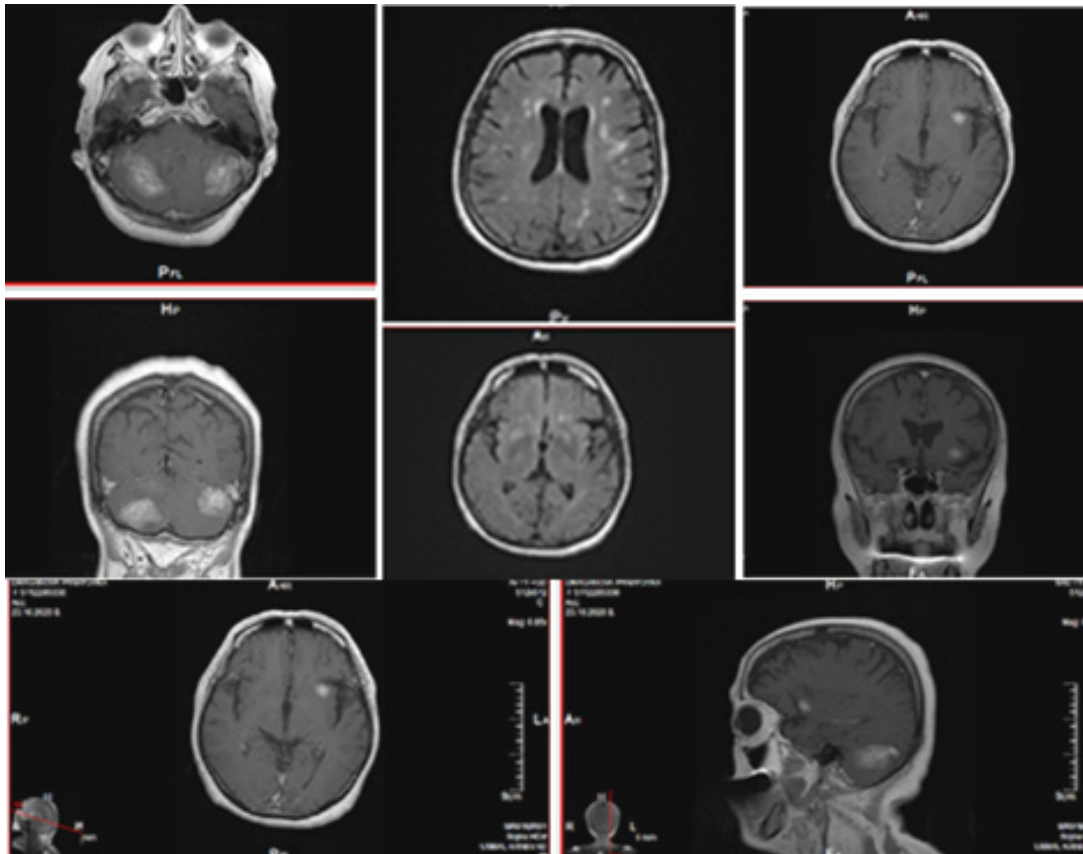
AX T1 FLAIR MRI, COR T1 FLAIR MRI and SAG T1 FLAIR MRI - postcontrast images showing hyperintense leptomeningeal brain lesions, mainly infratentorial in the cerebellum and supratentorial, without visible pathological signals subtitled in the medulla oblongata and in proximal cervical spinal cord.
